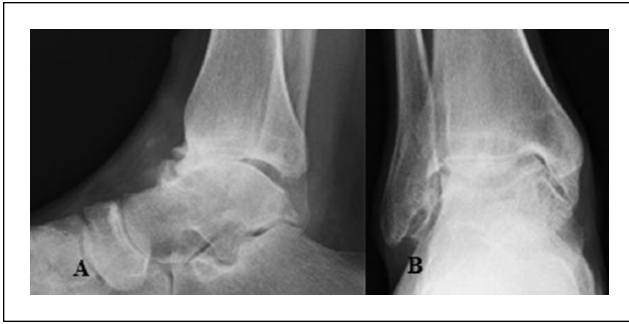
Preoperative X-rays of patient 2, lateral (A) and anterior-posterior (B) radiographs: ankle osteoarthritis with narrowing of the joint space and osteophytes (II stage according Van Dijk).
